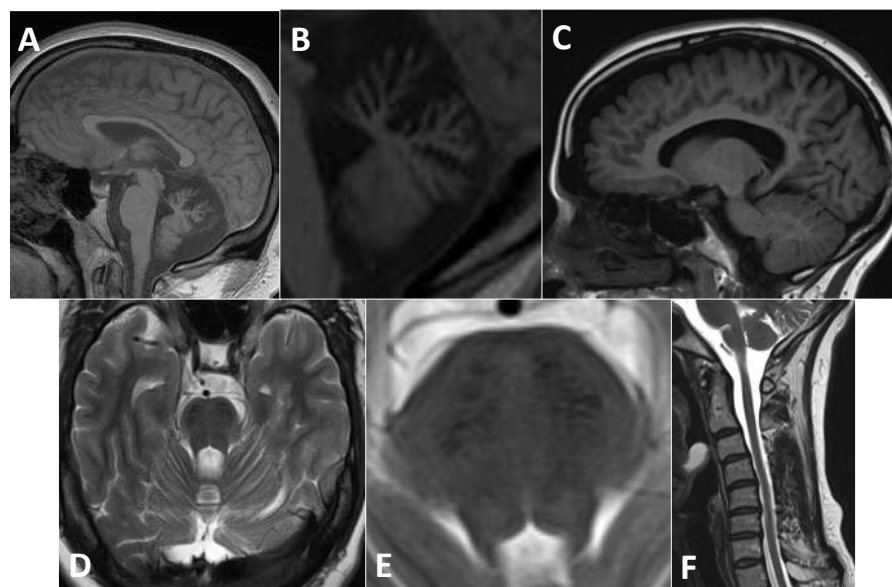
A) Sagittal T1 MRI showing superior vermis atrophy and corpus callosal thinning; B) Sagittal T1 MRI showing superior vermis atrophy; C) Sagittal T1 MRI showing generalized cerebral volume loss, most preponderant in the parietal lobe; D) Axial T1 MRI showing pontine hypointensities; E) Axial T2 MRI showing pontine hypointensities; F) Sagittal T2 MRI showing thinning of the cervical spinal cord
